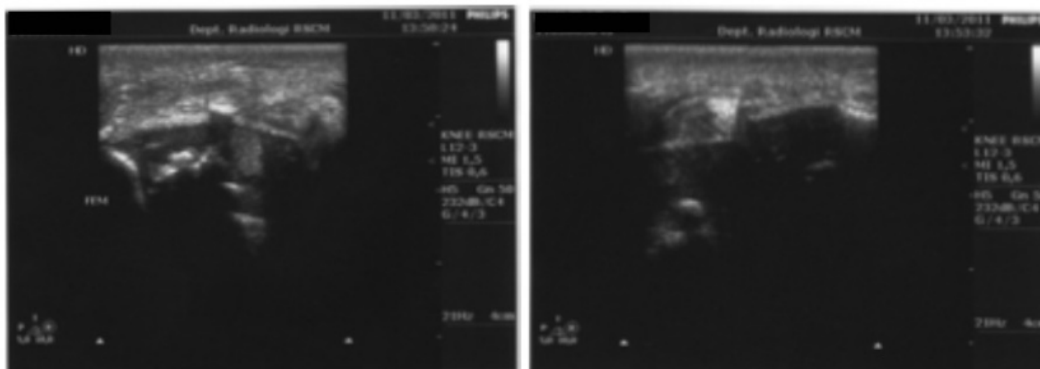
Ultrasound Examination of the Right Knee. The finding was marked joint effusion.
